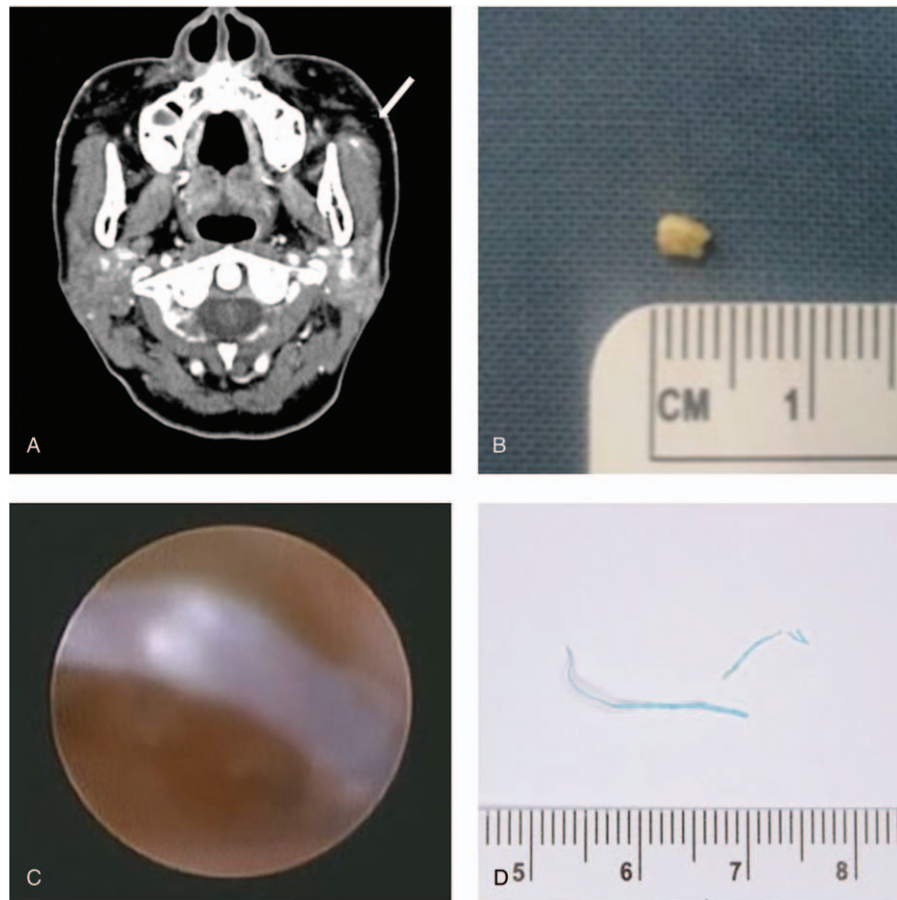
Computed tomographic and operative findings of case 1. (A) Axial enhanced neck computed tomograph showing a 0.4 cm sized stone in the superficial lobe of the left parotid gland with ductal dilatation (arrow), (B) 0.4 × 0.3 cm sized ductal stone removed by sialendoscopy, (C) Sialendoscopic finding showing the blue colored foreign body, which passed across the parotid ductal lumen, (D) The foreign body removed by sialendoscopy.
